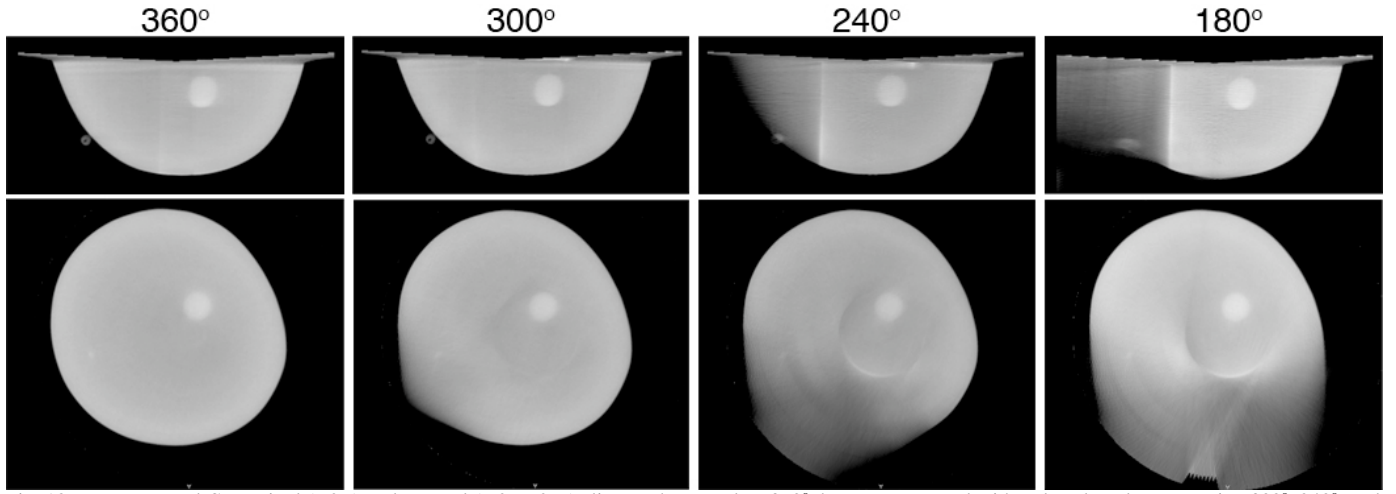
Reconstructed CT sagittal (TOP) and coronal (BOTTOM) slices. The complete 360° data are compared with reduced angle scans using 300°, 240°, and 180° of angular sampling. The central cone-beam ray was laterally offset 5cm resulting in truncation artifacts seen in the areas where projection views were not collected.
